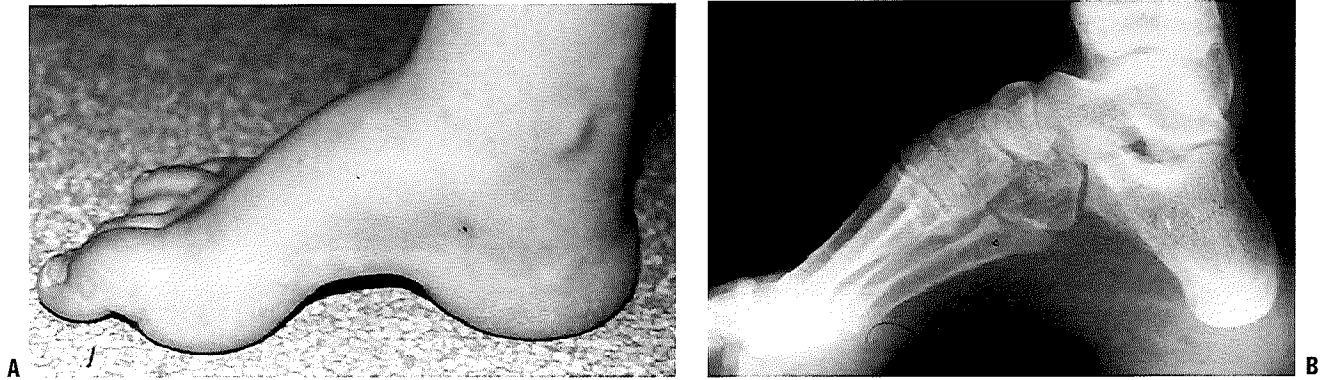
Calcaneocavus deformity in a child with myelomeningocele. A: Transtarsal cavus with thick callosities under the calcaneus and the metatarsal heads. B: Radiograph of the calcaneocavus “pistol-grip” deformity. (From the private collection of Vincent S. Mosca, MD.)
